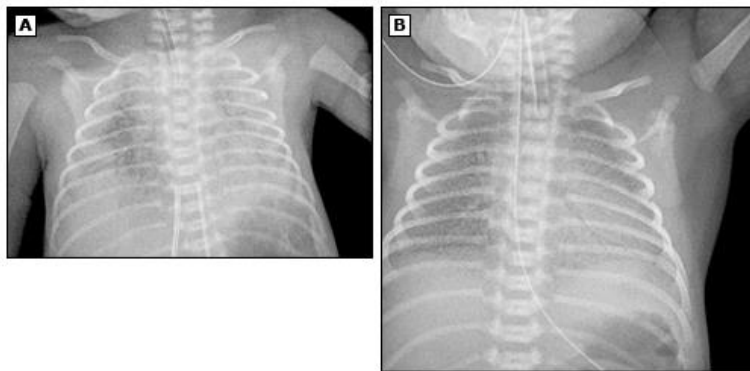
Chest radiograph of neonatal RDS. (A) shows the severe RDS which indicates the low lung volume compare to (B), moderate RDS which indicates high lung volume (14)
